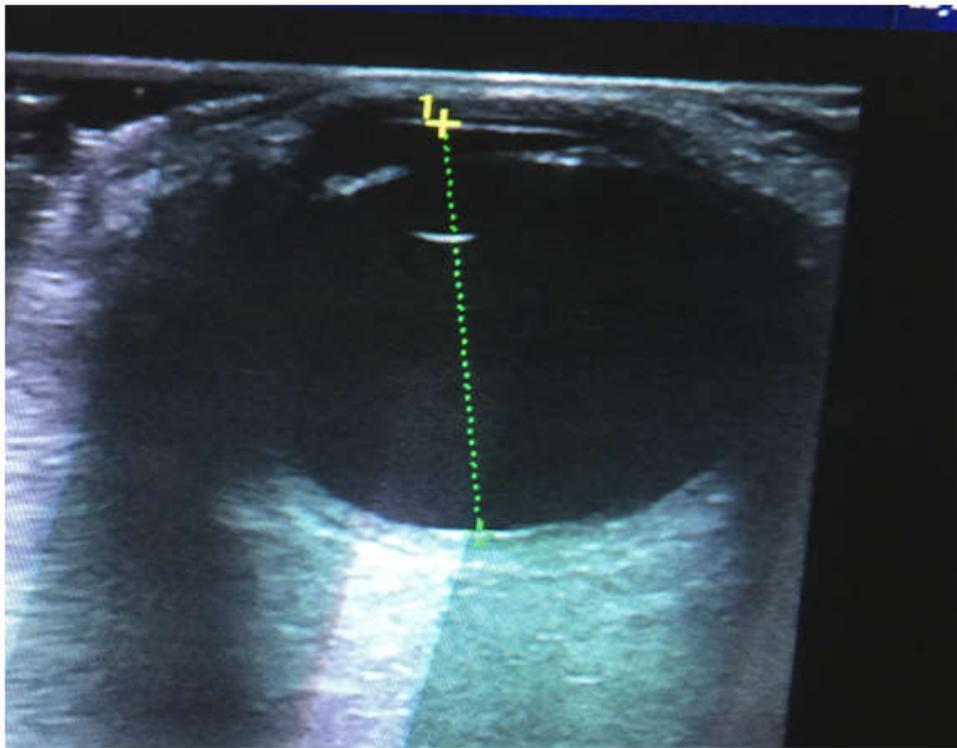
Transverse ocular sonogram showing the axial length of the globe
